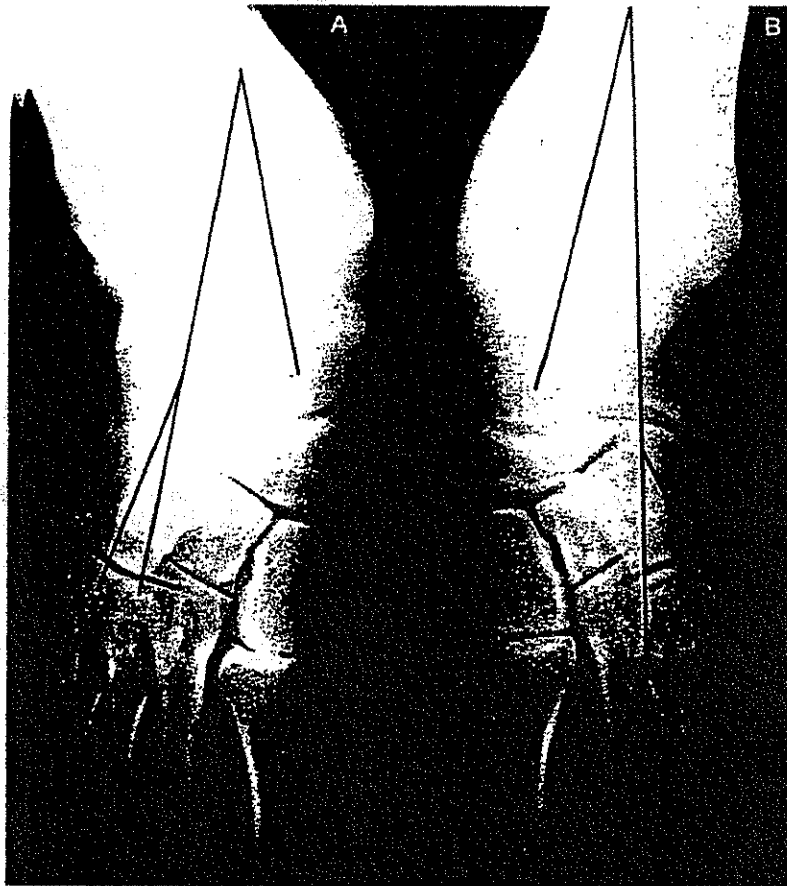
Anteroposterior roentgenograms of the feet of a 25-year-old male with left clubfoot deformity treated by seven plaster casts during infancy. At present, his functional rating is 93. The calcaneocuboid angle is drawn to assess hindfoot-midfoot alignment and measures (A) -9° in the normal foot and (B) -27° in the clubfoot. The talocalcaneal angle measures 21° in the normal foot and 15° in the clubfoot. The incomplete correction of the talocalcaneal angle in the clubfoot is compensated by the increased abduction of the midfoot. In the clubfoot, the navicular is small and wedge shaped; it articulates with a talar head of diminished sphericity.
